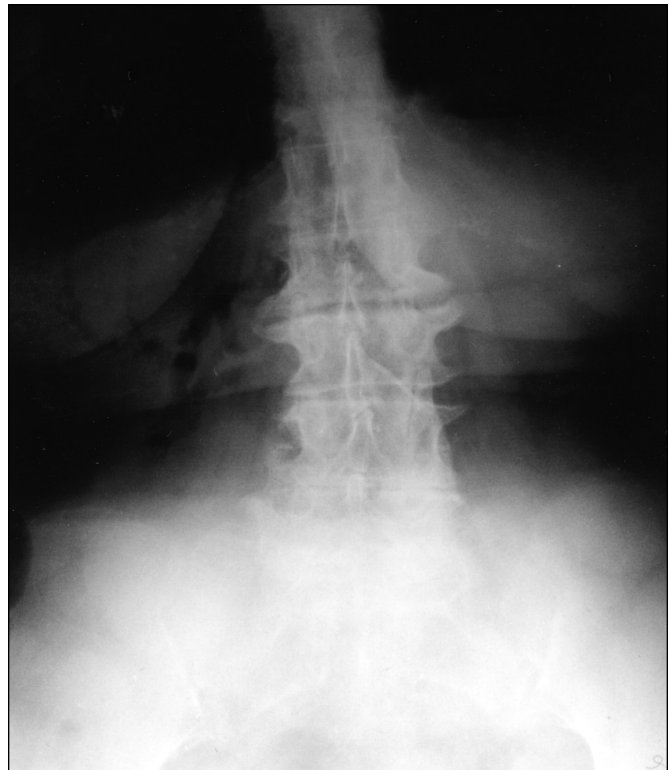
Plain abdominal radiograph of patient 1 demonstrates pneumobilia.
